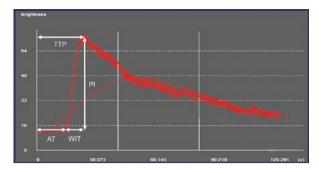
Time-intensity curve (TIC) from region of interest (ROI) within the tumor and the ultrasound TIC parameters. Peak intensity (PI), Arrival time (AT), time to peak enhancement (TTP), wash-in-time (WIT)
